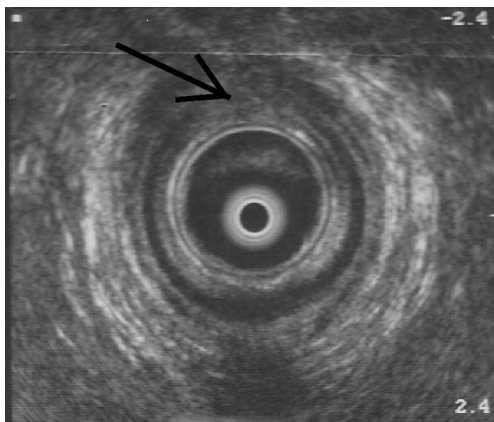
Actual endoanal ultrasound image of a study subject with an internal anal sphincter tear, indicated by the *black arrow*
